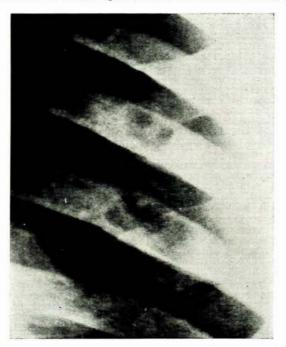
Radiograph showing punched-out translucencies in the medulla of 6th and 7th ribs.
